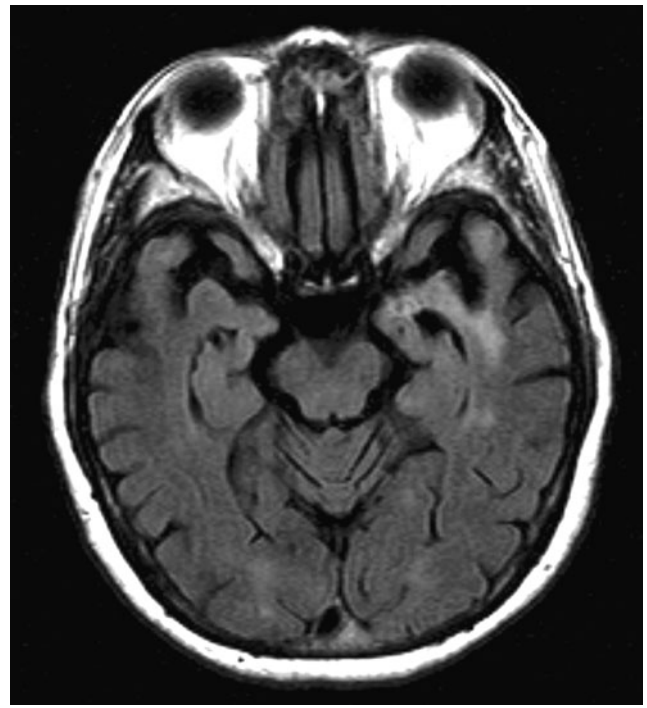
Magnetic resonance imaging fluid attenuation recovery demonstrating increased signal in the anterior left temporal lobe demonstrating secondary gliosis in a patient previously treated for herpetic encephalitis.
